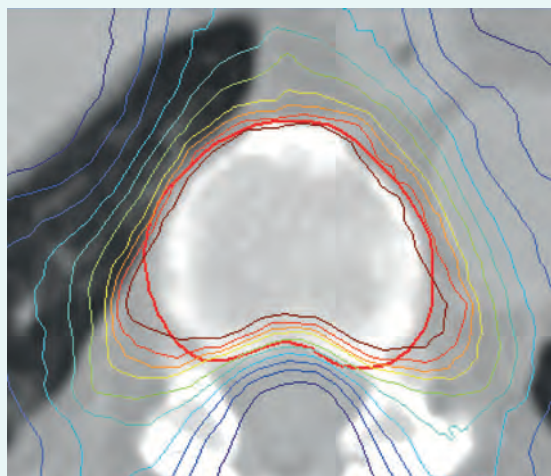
An example CT slice showing a bony PTV in a clinical spine SABR plan.
